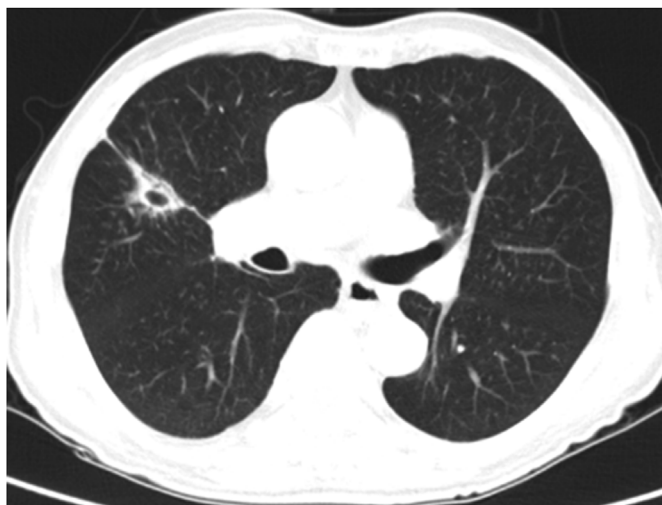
The narrowing lung lesion and formation of an obvious cavity were shown on chest CT scan after enhanced antibiotic therapy.
